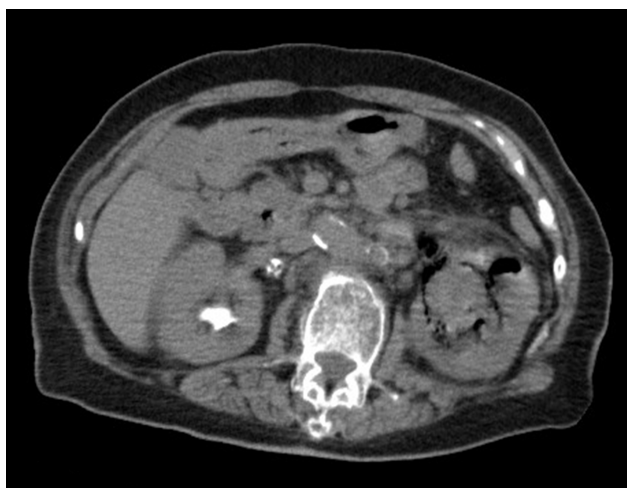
Abdominal computed tomography showing left emphysematous pyelonephritis
